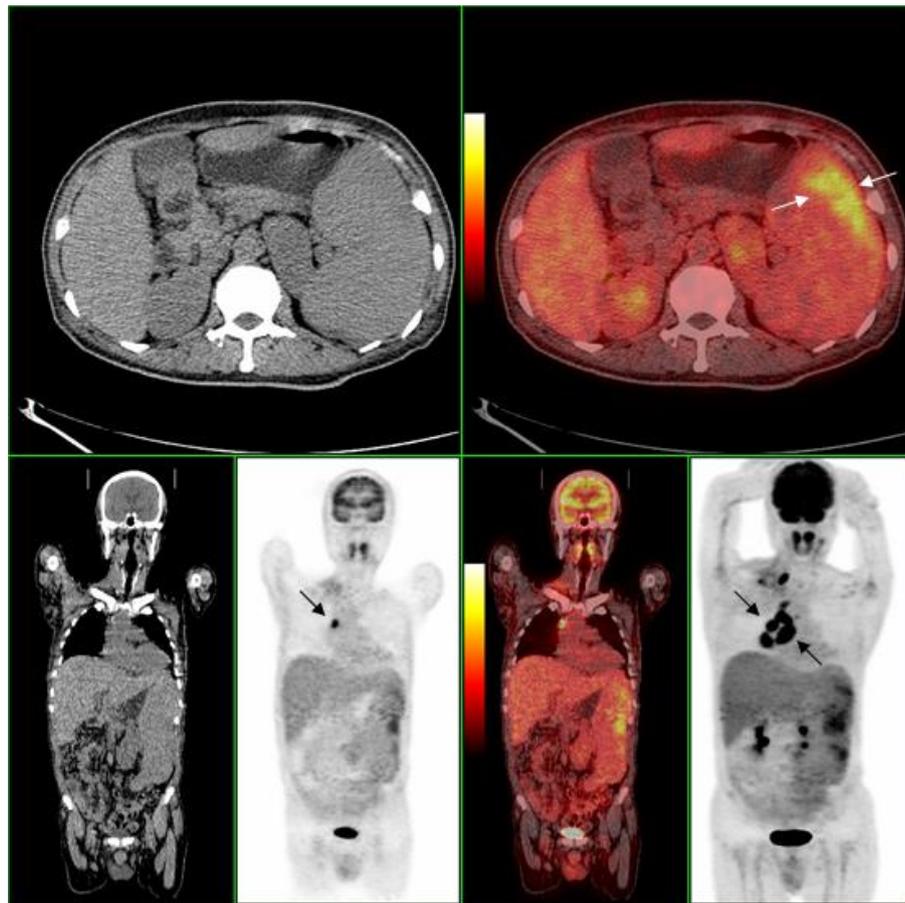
Stage III NSHL with splenic involvement in a 67-y-old man. The axial and coronal ^{18}F -FDG PET image shows increased splenic local uptake of ^{18}F -FDG, which is greater than hepatic uptake (white arrows). The spleen index was 3328 mL, with S/L ratio of 1.6. Coronal PET/CT and projection images show multiple high metabolism lymph nodes (black arrows).
